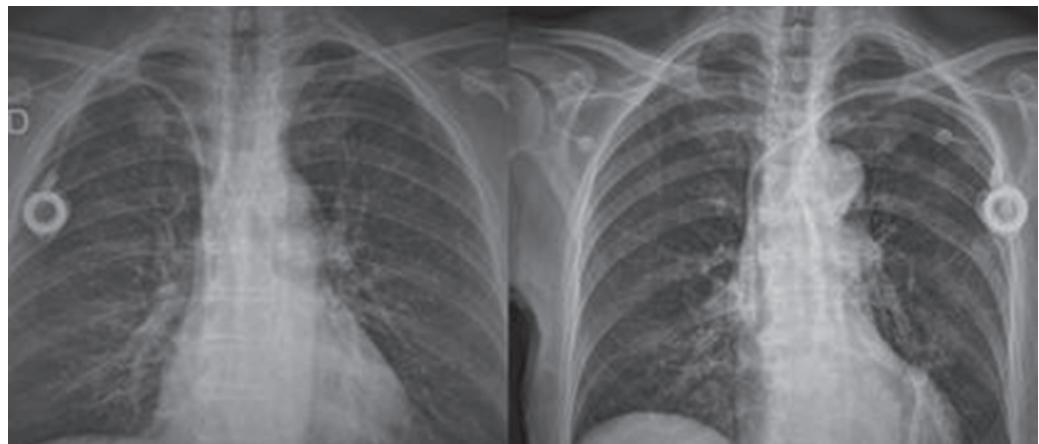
Control chest Xrays after totally implantable venous access port implant showing less curvature of the catheter on the left side.
